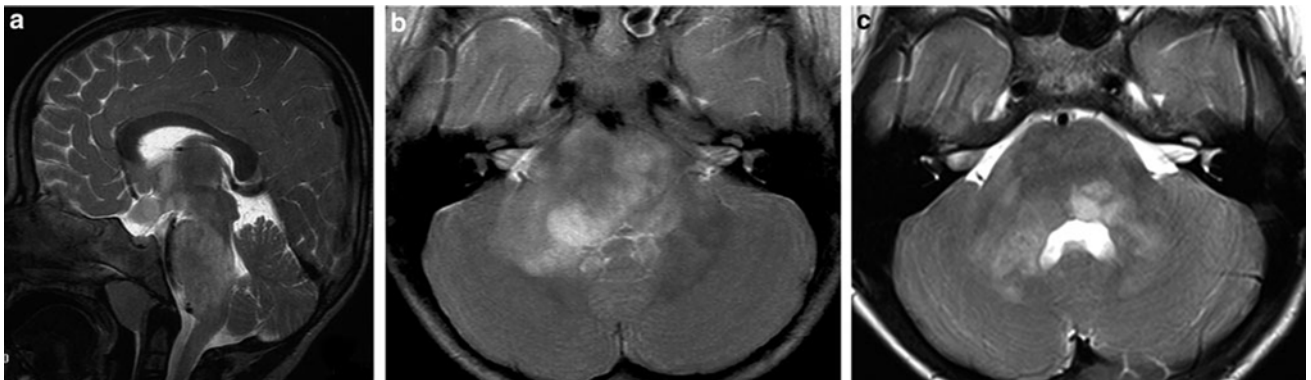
Sagittal (a) and axial (b) T2-weighted images of a 4-year-old child with neurofibromatosis I and only very mild brainstem symptoms. Five years later (c) the swelling of the pons markedly regressed
